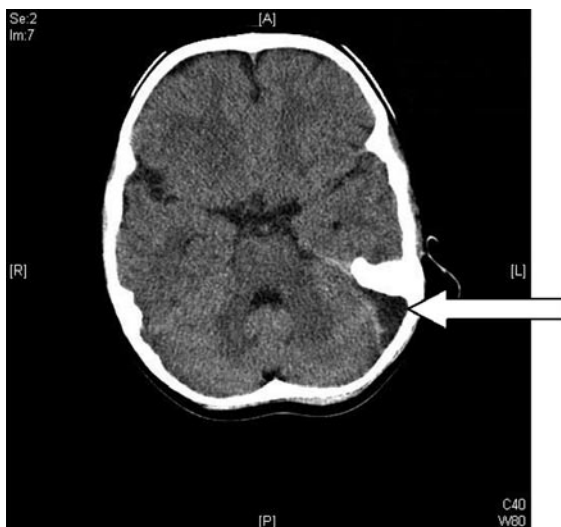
CT scan showing cerebral abscess.
